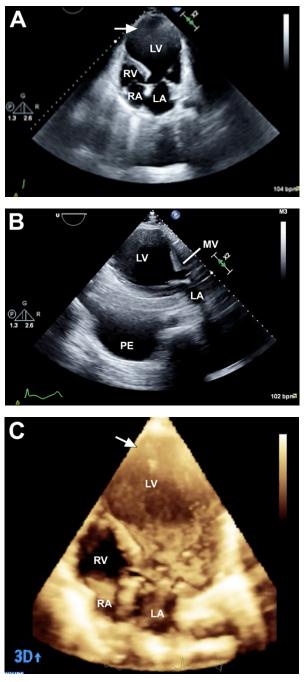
A) Transthoracic echocardiogram shows a 9.1-cm left ventricular (LV) aneurysm (arrow) at end-systole (apical 4-chamber view). Severe LV dilation, systolic dysfunction, and spontaneous echo contrast are seen in the B) parasternal long-axis view and in C) 3D mode. In addition, a large left pleural effusion (PE) is seen in B, and an aneurysm (arrow) within the LV cavity in C.
